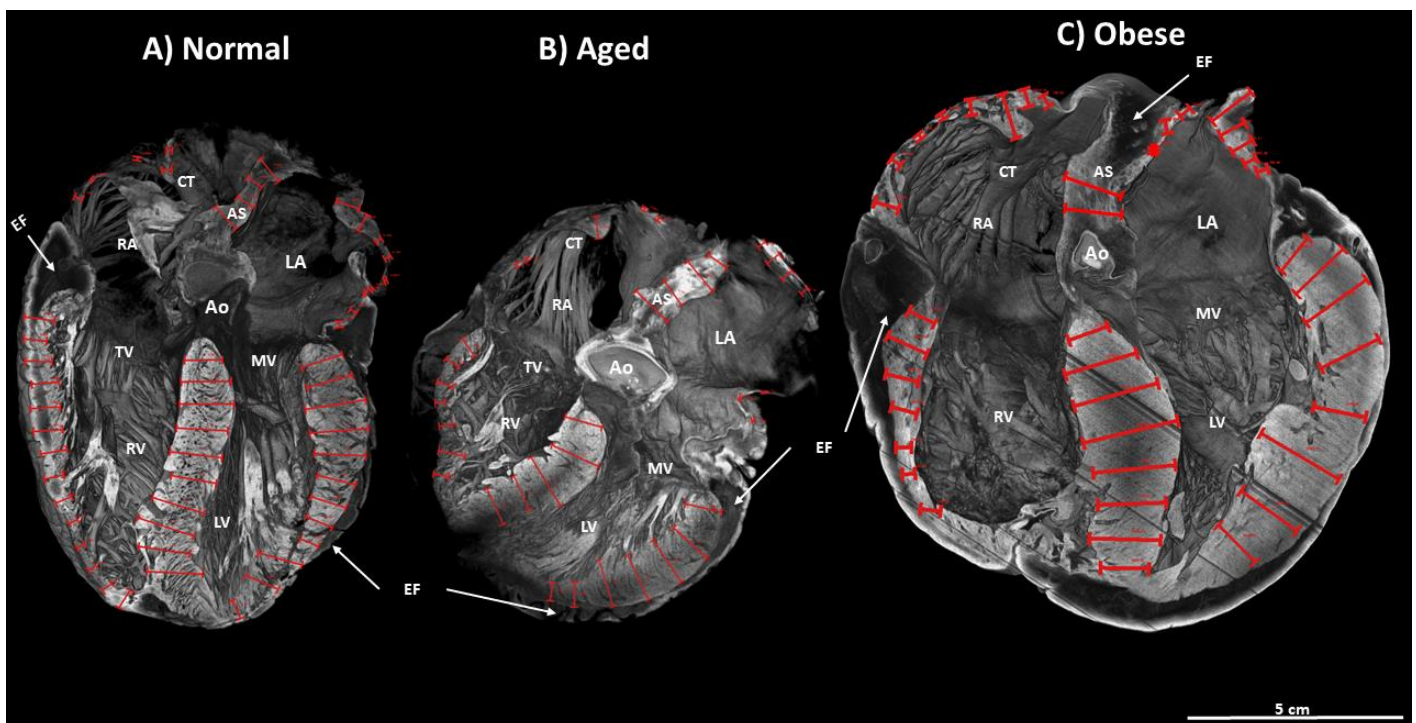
Long axis four chamber view of the normal, aged and obese hearts, showing the location of the myocardial wall width measurements. (A), normal heart. (B), aged heart. (C), obese heart. Red lines indicate location and position of measurements. n=1 normal heart; n=1 aged heart; n=1 obese heart. Ao = aorta; AS = atrial septum; CT = crista terminalis; EF = epicardial fat; LA = left atrium; LV = left ventricle; MV = mitral valve; PPM = posterior papillary muscle; RA = right atrium; RV = right ventricle; VS = ventricular septum.
